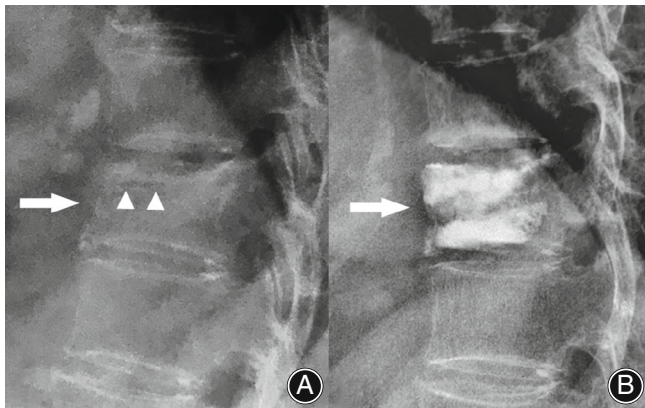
Lateral view of spinal X-rays centered on T11 vertebra pre and post-operation on 3 days. The pre-operation X-rays indicate the IVC (A, arrowheads) within the wedge-shaped changes of T11 vertebra (A, arrow). The post-operation X-rays (B, arrow) show the restoration of T11 vertebral height, filling with bone cement without leakage.
